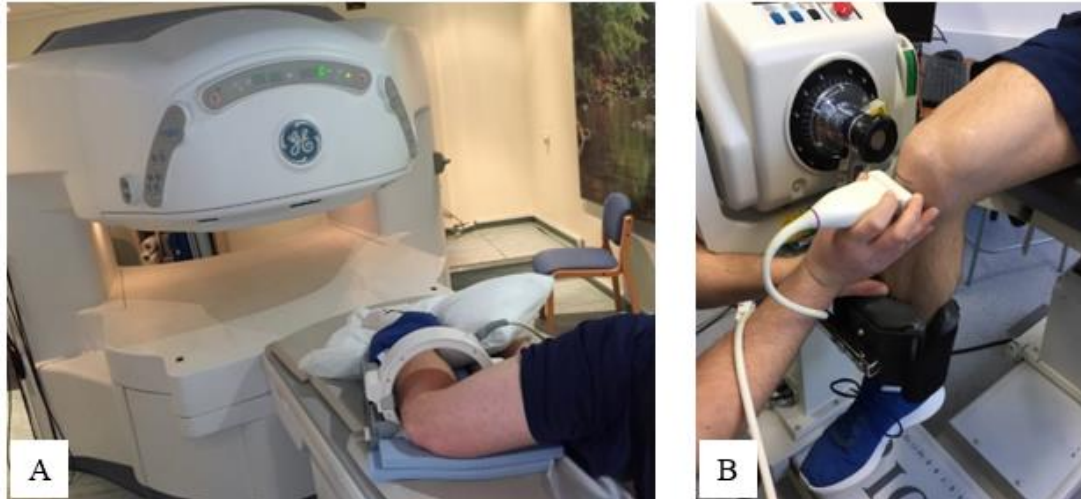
Scanning position prior to the MRI scan (A) and scanning position for US imaging (B).
